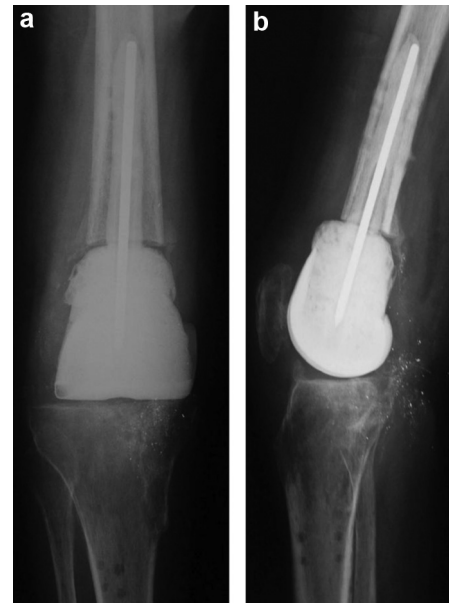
a, b: AP and lateral X-ray: reinforced cement spacer to maintain limb length.
